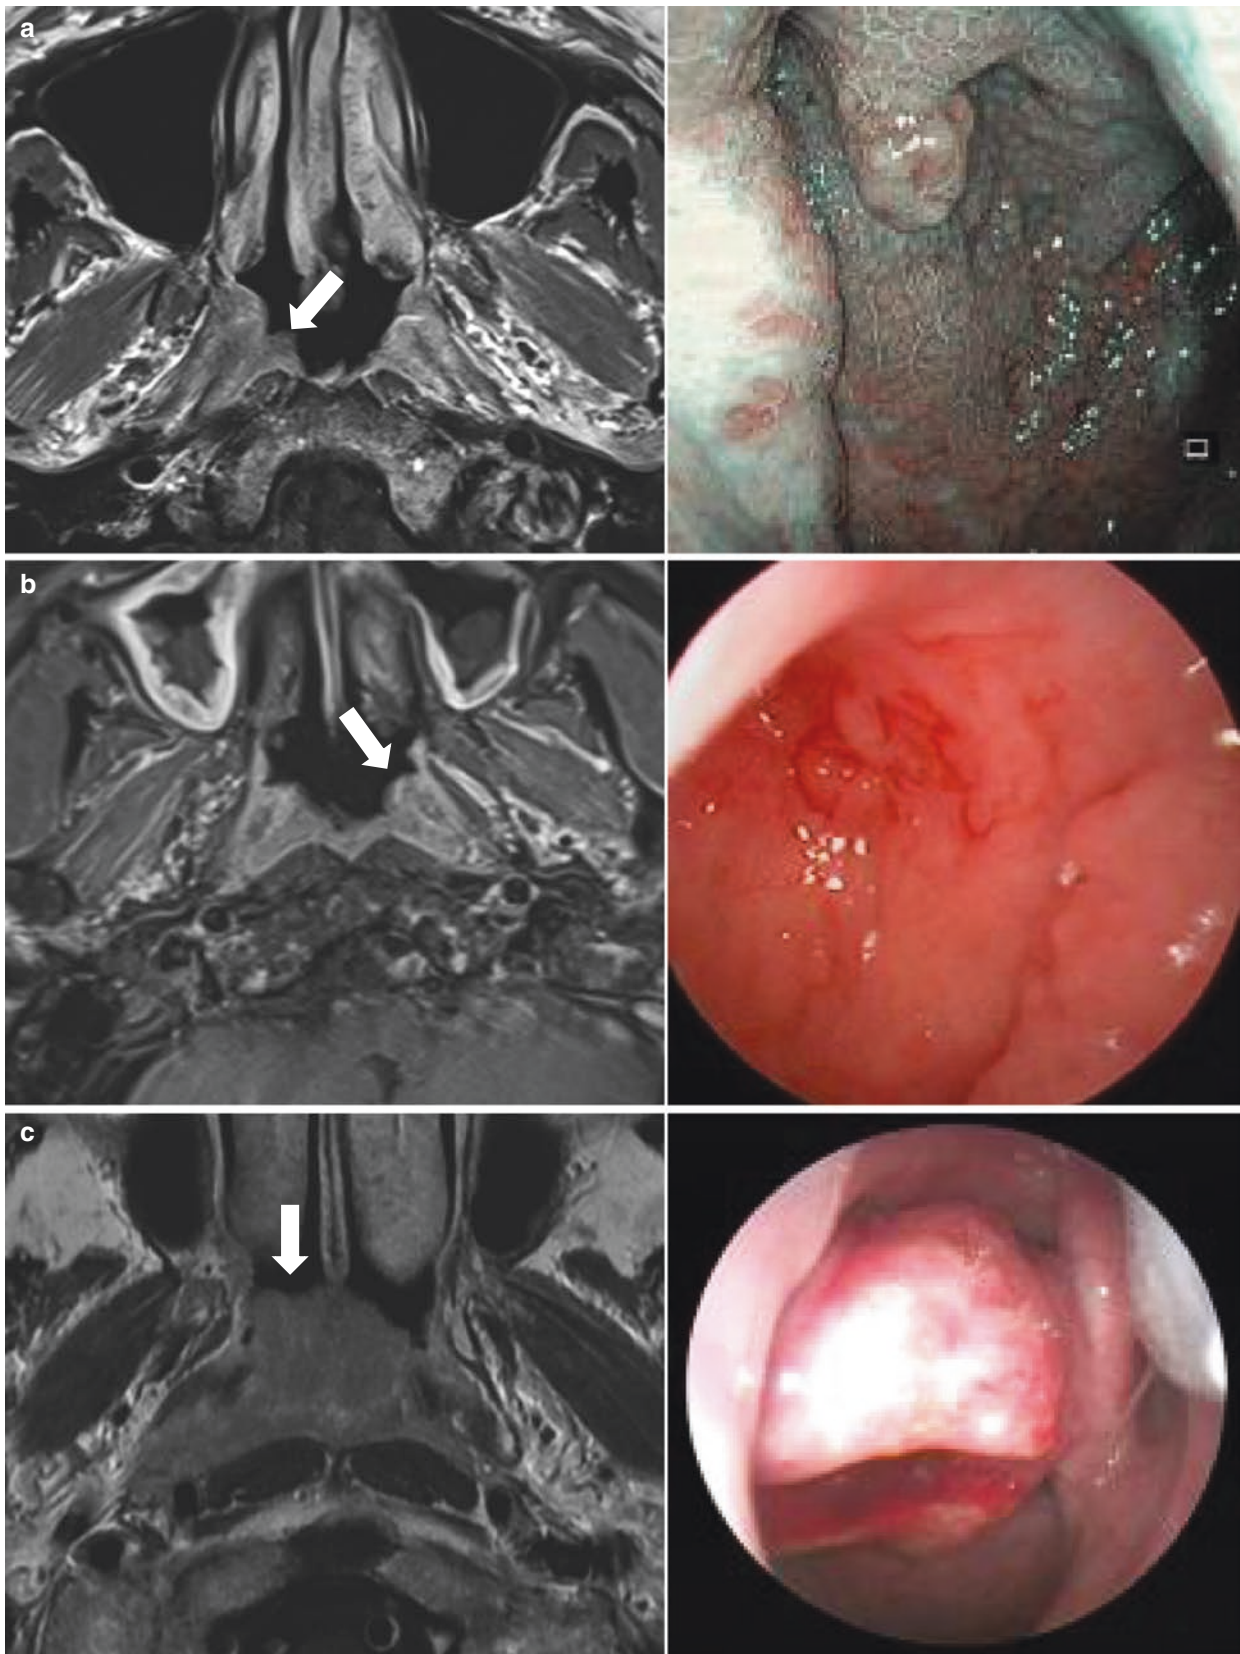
Synergy of MRI and endoscopic assessment. MRI images (left column) and corresponding endoscopic pictures (right column) highlighting the importance of evaluating even subtle asymmetries.
